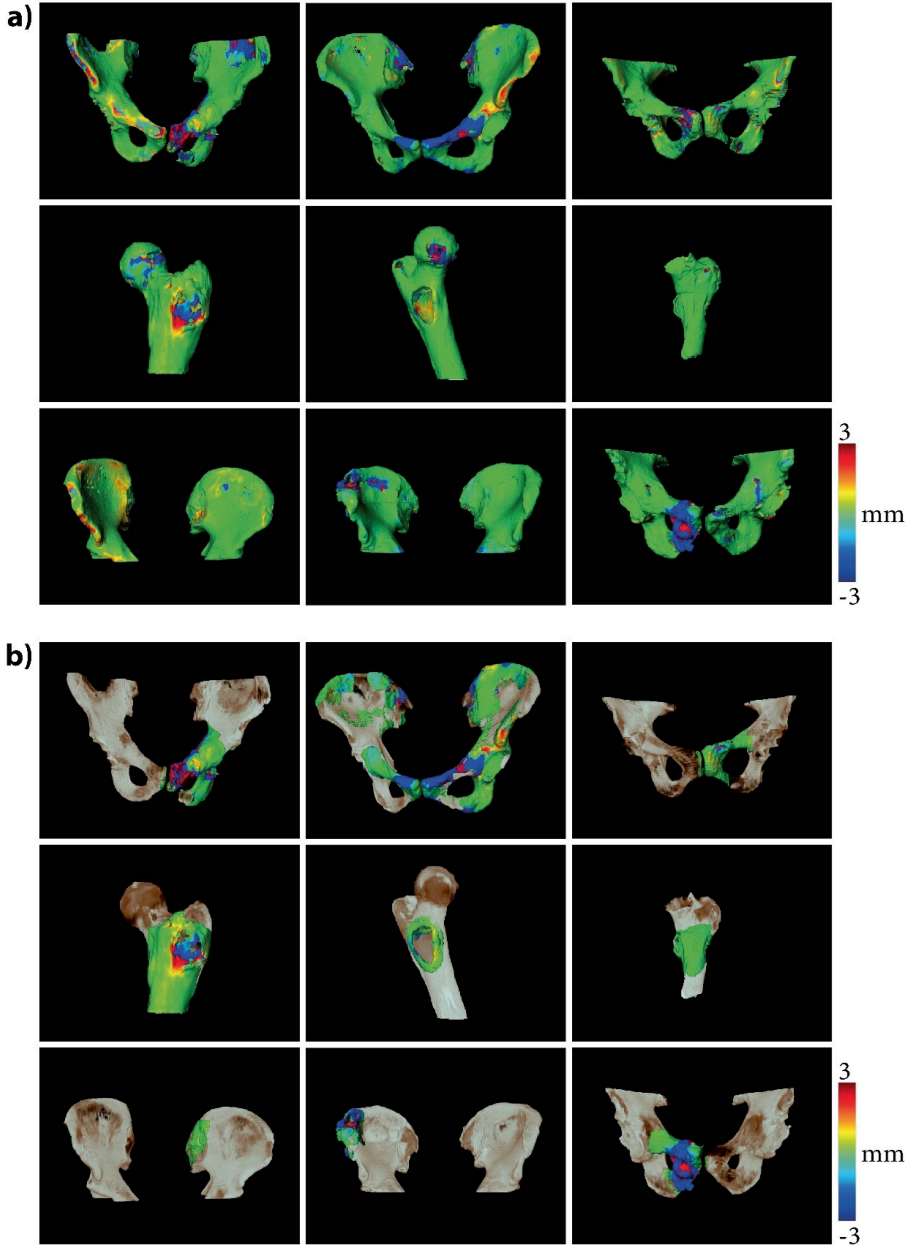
S1: sCT-to-CT surface distance maps of the patients images obtained in this study, (a) in the entire bone, (b) on a 3 cm margin around and including the lesion.
